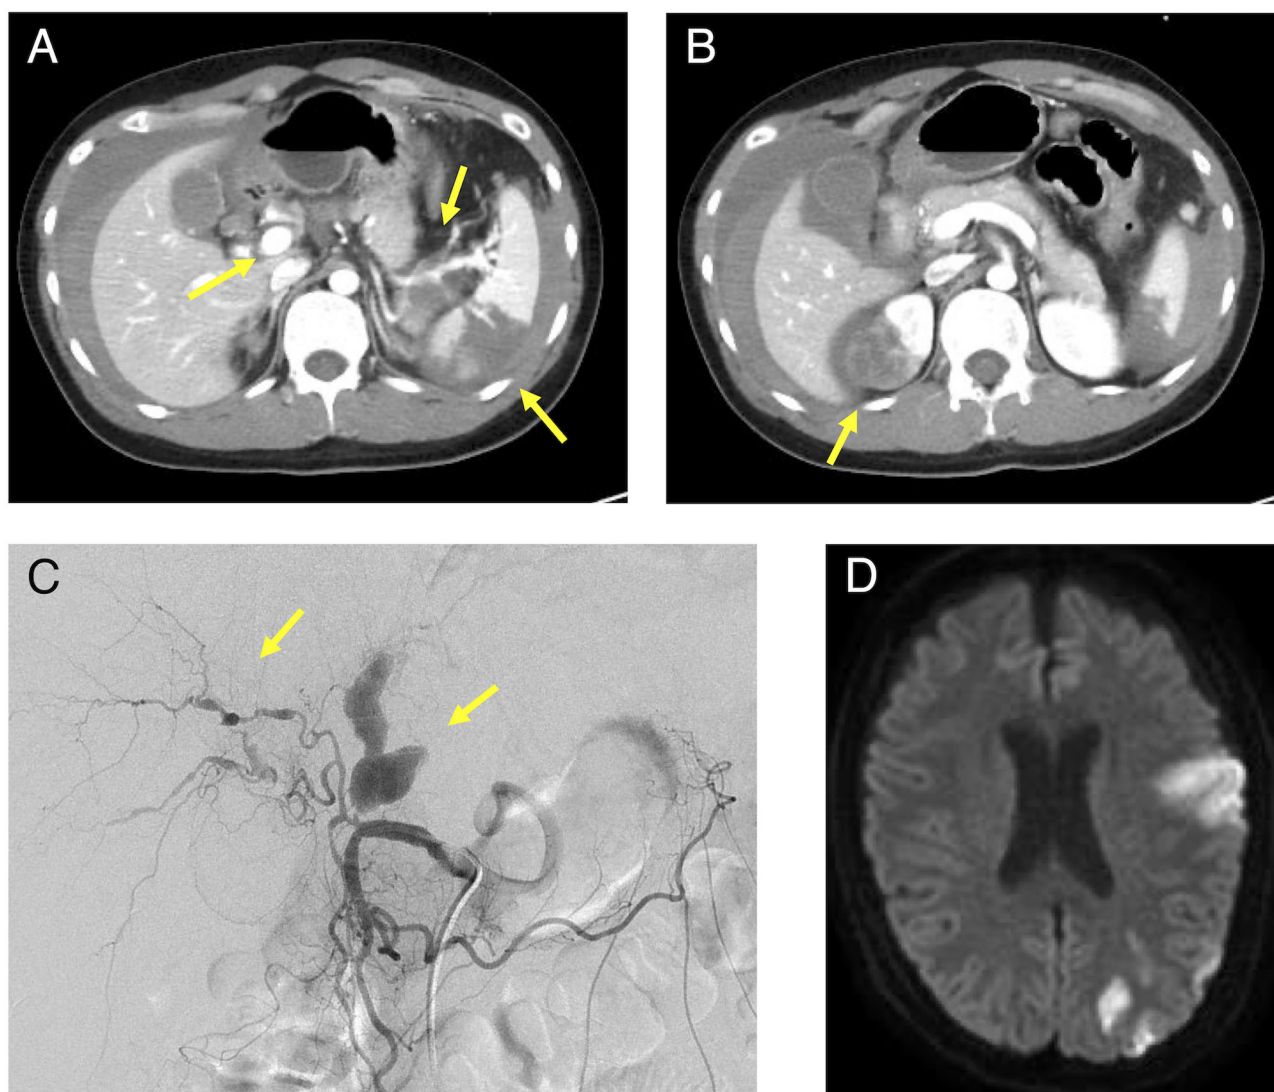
Contrast-enhanced CT, angiography, and head MRI of the patient. (A): Intra-abdominal hemorrhage, splenic infarction, and hepatic and splenic artery aneurysm were observed in the area indicated by the arrow and (B): Right renal infarction was observed in the area indicated by the arrow on the contrast-enhanced abdominal CT. (C): A proper hepatic artery aneurysm was observed in the area indicated by the arrow on angiography. (D): A cerebral infarction was observed in the left middle cerebral artery territory on the plain MRI of the brain. MRI, magnetic resonance imaging; CT, computed tomography.
